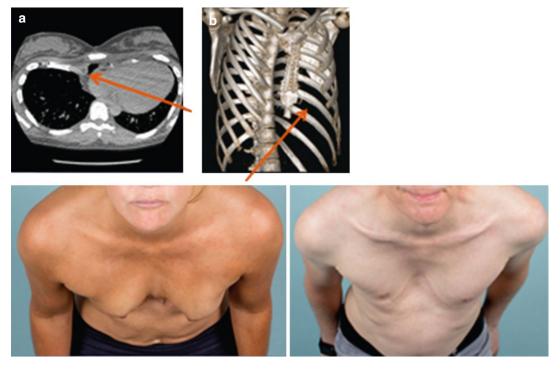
Malunion and recurrence of pectus excavatum defect after previous Ravitch repair are seen in these patient's photographs, computerized tomography and 3-D reconstruction images (a) A 46 year-old female with significant recurrence after open Ravitch procedure. CT scan
